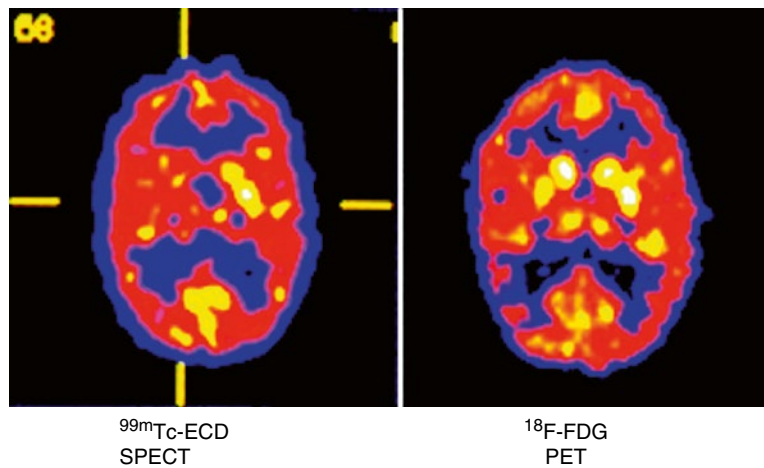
Six-week-old infant with seizures. Patient had recurrent convulsions with the head turning left and stiffening of the right side of the body. A computed tomography (CT) scan at 10 days of age showed evidence of hemorrhage in the left frontal periventricular white matter as well as prominent cortical sulci. Magnetic
